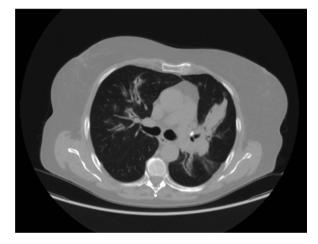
High-resolution chest computed tomography of the lung performed in February 2021, showing an untypical image of intense thickening of bronchial walls and peribronchial infiltrations in the lower lobes of both lungs and a 30 mm area of consolidation in the 5th segment of the right lung
